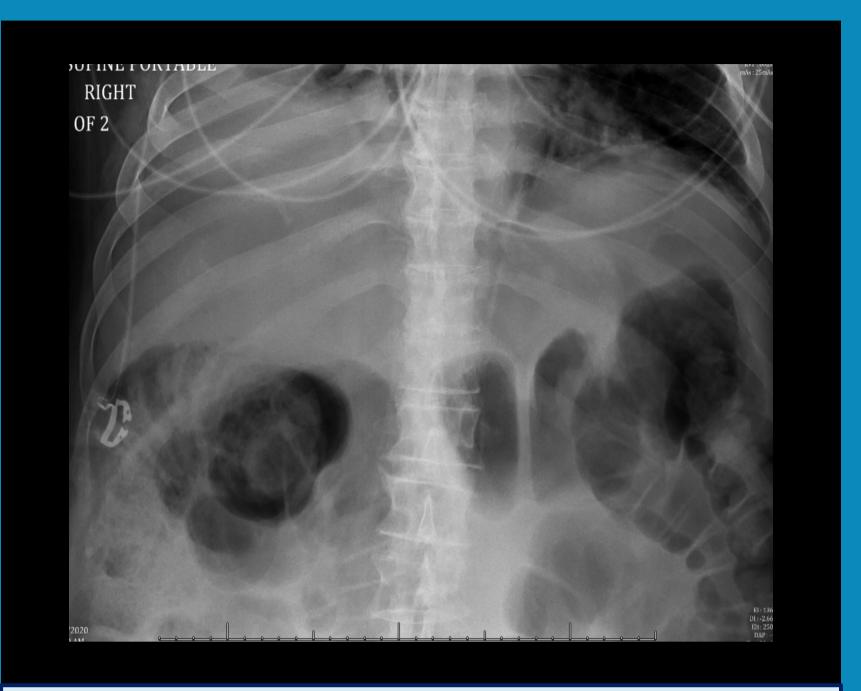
Abdominal x-ray Generalized colonic ileus pattern with gaseous delineation of nondilated loops of small bowel.
